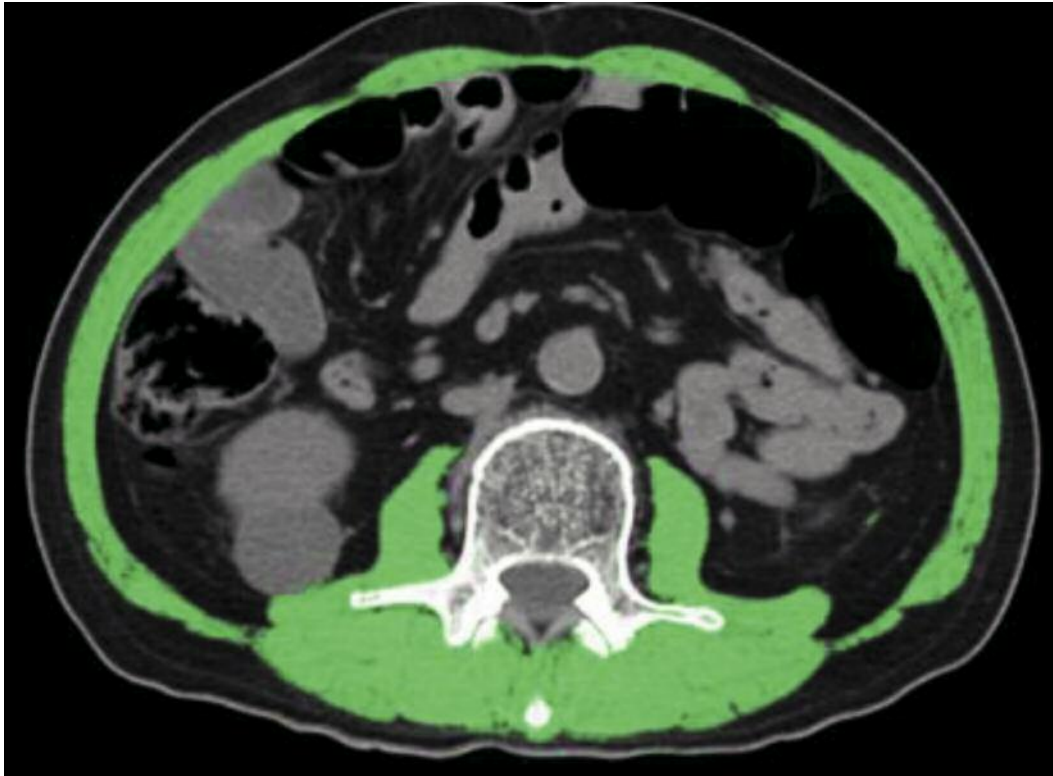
Evaluation of sarcopenia on CT imaging. The total cross-sectional skeletal muscle area (SMA) (green) at the third lumbar level (white) is evaluated using SYNAPS VINCENT.
